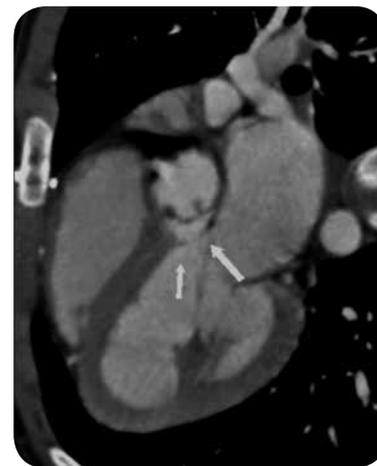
21-year-old patient with multiple cardiovascular malformations, including LVOT membrane, partial pulmonary venous drainage abnormality and abnormal papillary muscles of the left ventricle with septal insertions. Correction of CIV. Cardio CT with reconstruction in long axis three chambers where an oblique membrane is observed in the LVOT (arrows).
